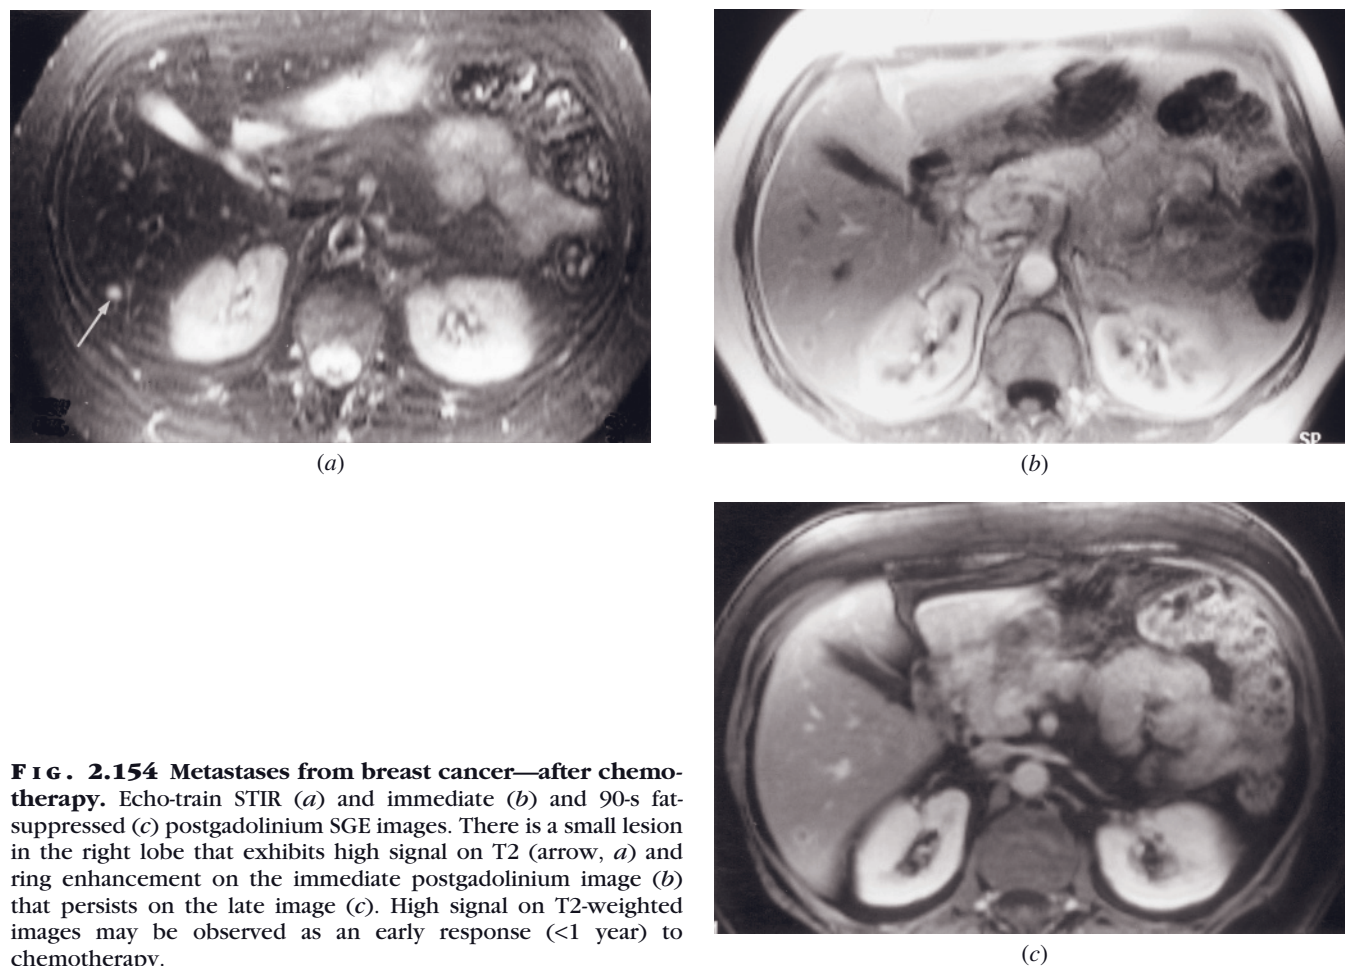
Metastases from breast cancer—after chemotherapy. Echo-train STIR (*a*) and immediate (*b*) and 90-s fat-suppressed (*c*) postgadolinium SGE images. There is a small lesion in the right lobe that exhibits high signal on T2 (arrow, *a*) and ring enhancement on the immediate postgadolinium image (*b*) that persists on the late image (*c*). High signal on T2-weighted images may be observed as an early response (<1 year) to chemotherapy.
